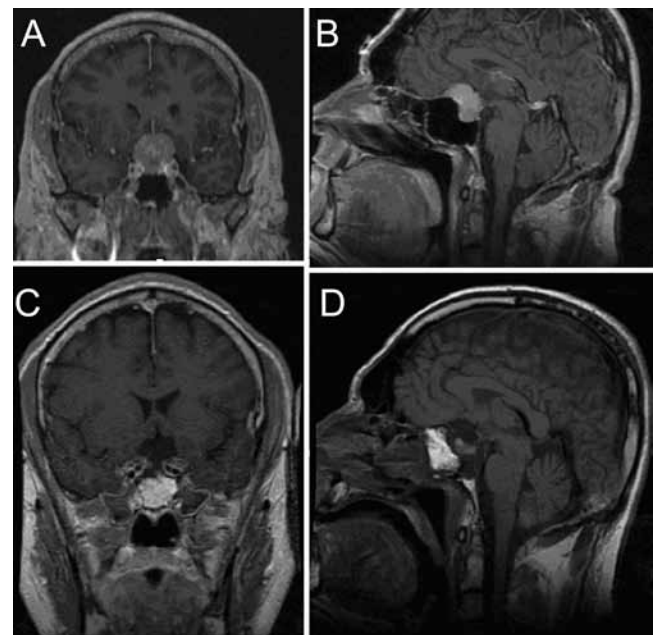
Case 7. Preoperative coronal (A) and sagittal (B) contrast-enhanced T1-weighted MR images showing a large TSM with inferior sellar extension. Postoperative coronal (C) and sagittal (D) contrast-enhanced T1-weighted MR images showing GTR of the TSM.
